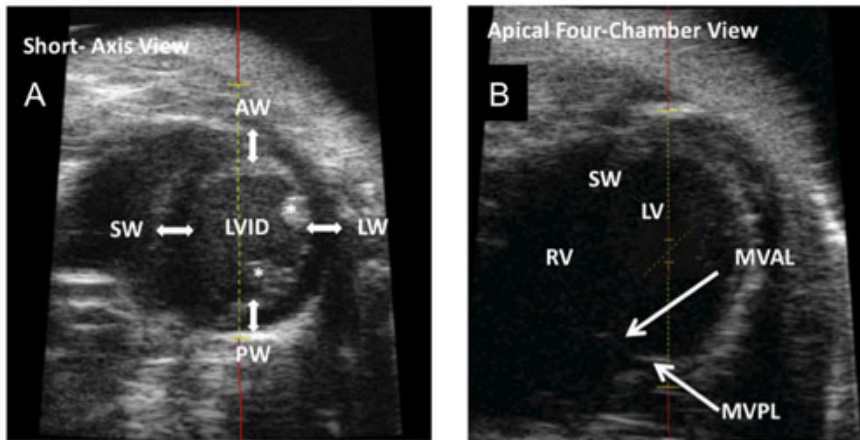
Representative 2D Echocardiography Images (B-mode). (A) Para-sternal short-axis view showing the left ventricular anterior (AW) and posterior (PW) walls, the intraventricular septal wall (SW), and lateral wall (LW). The diameter of the left ventricular lumen can be measured as the left ventricular internal diameter (LVID). The asterisk indicates the posteromedial papillary muscle. (B) Apical four-chamber view with a viewing area over the mitral valve for determination of E/A peak velocities. MVAL, mitral valve anterior leaflet; MVPL, mitral valve posterior leaflet; RV, right ventricle; LV, left ventricle.
